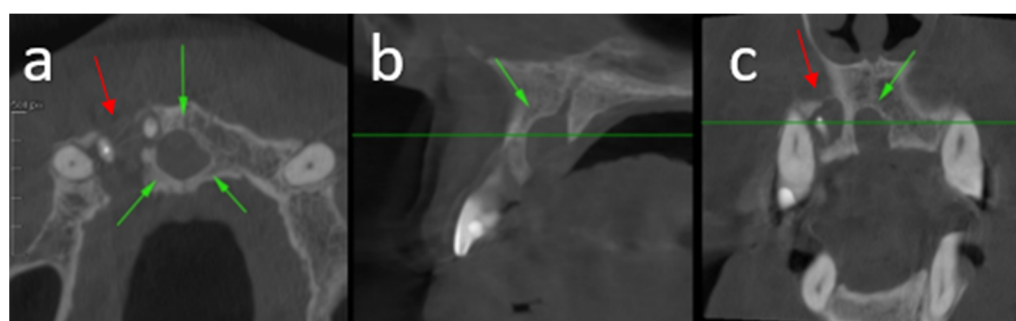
Cone beam computed tomography (CBCT) in axial (a), sagittal (b), and coronal (c) planes demonstrating a well-defined radiolucent lesion centered on the nasopalatine canal, consistent with a nasopalatine duct cyst, with associated palatal cortical dehiscence. An additional adjacent cystic lesion of radicular origin is observed, primarily centered at the apex of the non-vital tooth 12, associated with buccal and palatal cortical dehiscence, extending into contact with the apices of teeth 11 and 13. Green arrows indicate the nasopalatine duct cyst. Red arrows indicate the radicular cystic lesion.
